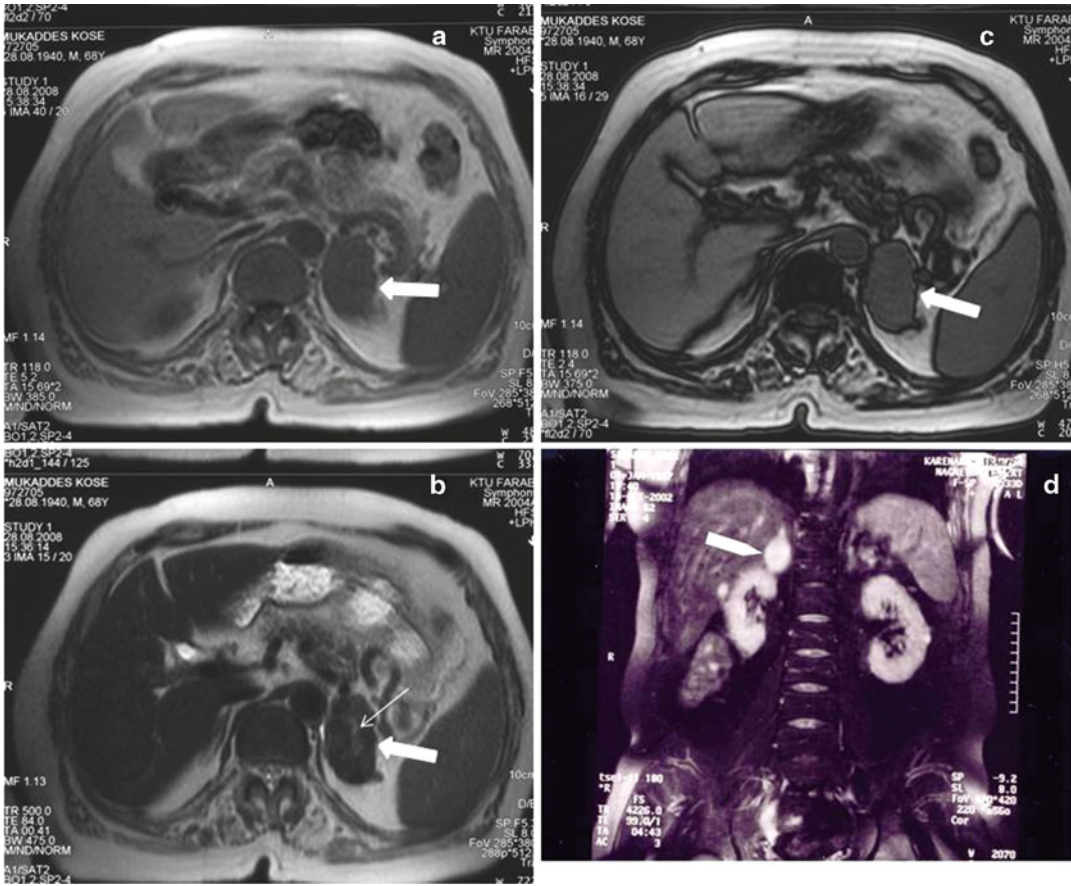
(a) Transverse T1-weighted MRI shows a oval, slightly lobulated left adrenal ganglioneuroma that measures 60×45 mm (*arrow*). The mass is homogeneous, with signal intensity less than that of liver (hypointense), (b) Transverse T₂-weighted MRI scan demonstrating oval heterogeneous mass (*thick arrow*) with slightly high signal intensity greater than that of liver and with central crescent-shaped calcifications in left adrenal
